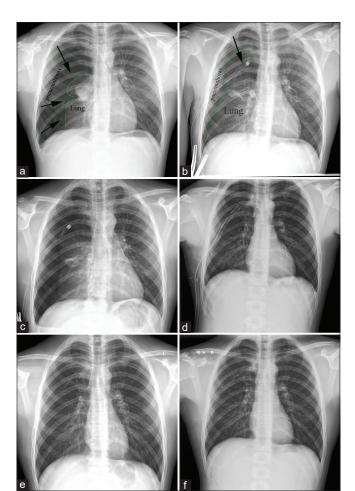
(a) Chest X-ray demonstrating an 80% right-sided pneumothorax; (b) chest X-ray taken half an hour after chest tube placement, demonstrating partial resolution; (c) chest X-ray taken next morning after admission showing no further resolution; (d) chest X-ray taken following video-assisted thoracoscopic surgerybullectomy; (e) follow-up chest X-ray 6th day after surgery; and (f) follow-up chest X-ray 1 month after surgery showing complete resolution of pneumothorax. The following day, a VATS-bullectomy of the right upper lobe was performed through three access ports. Apical pleurectomy followed to achieve mechanical pleurodesis (Fig. 1d). Postoperatively, the chest tube with the Heimlich valve was removed on the fourth postoperative day after full reexpansion of the lung was achieved. No postoperative air leak was observed. A follow-up chest X-ray taken on the 6th day after surgery revealed that the pneumothorax had completely resolved (Fig. 1e). One month after the initial presentation, the patient is in great clinical condition and has returned to sports activities and there were no signs of a recurrence of spontaneous pneumothorax (Fig. 1f).
